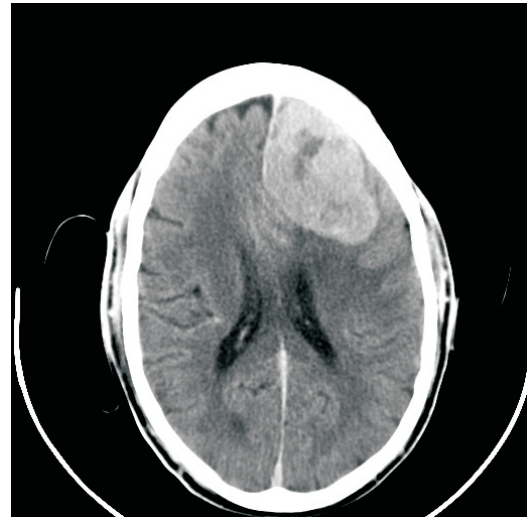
Contrast enhanced Cranial CT of the same patient as in figure 1. The lesion enhanced moderately apart from the region of necrosis earlier mentioned in the legend to figure 1.
